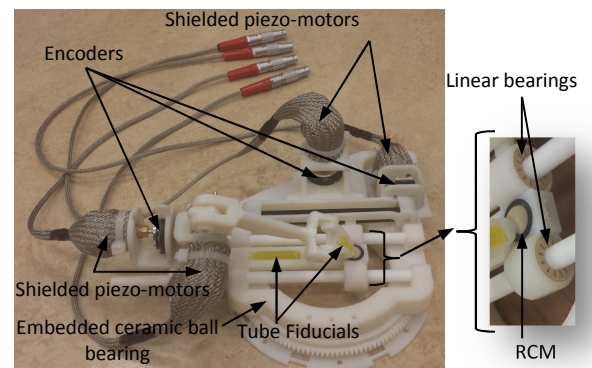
New MRI-compatible robot with shielded motors and cables. Tube fiducials are embedded in the design for Robot/image registration.
